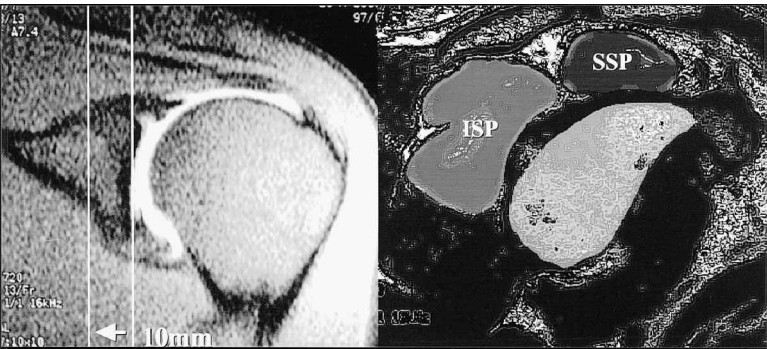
Cross-sectional area (CSA) of the supraspinatus and infraspinatus muscles on T1-weighted MR images in the oblique sagittal plane, 10 mm proximal to the glenoid surface.
